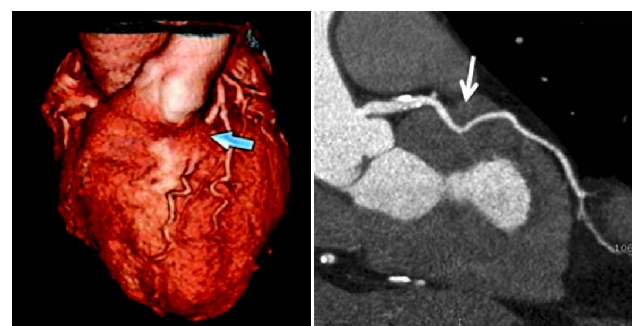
Multi Detector CT (MDCT) angiogram showing proximal LAD segment (arrows) in a deep myocardial bridge (> 2 mm).
